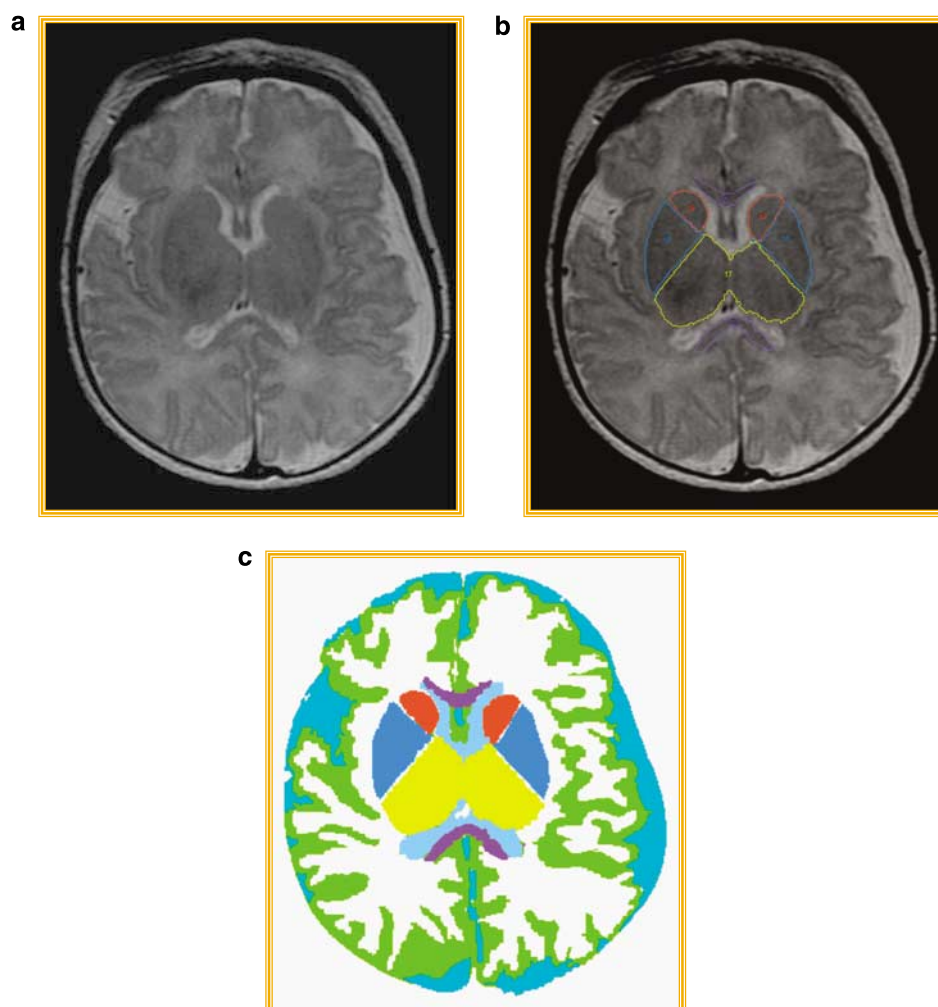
Representative example of brain volume segmentation and labeling methodology for an axial T2-weighted brain MRI. (a) Unsegmented T2-weighted midbrain MRI slice. (b) Manual segmentation and labeling of smaller subcortical structures: (purple), corpus callosum; (yellow), thalamus; (blue), lenticular nucleus; (red), caudate nucleus. (c) Fully segmented mid-axial slice. Representative pixels were individually sampled from the lateral ventricles (light blue), subcortical white matter (white) and cortical gray matter (green) and segmented using a semiautomatic segmentation tool. Extra-axial CSF (cyan) spaces were sampled and labeled last, on the basis of location and clear regional intensity differences.
